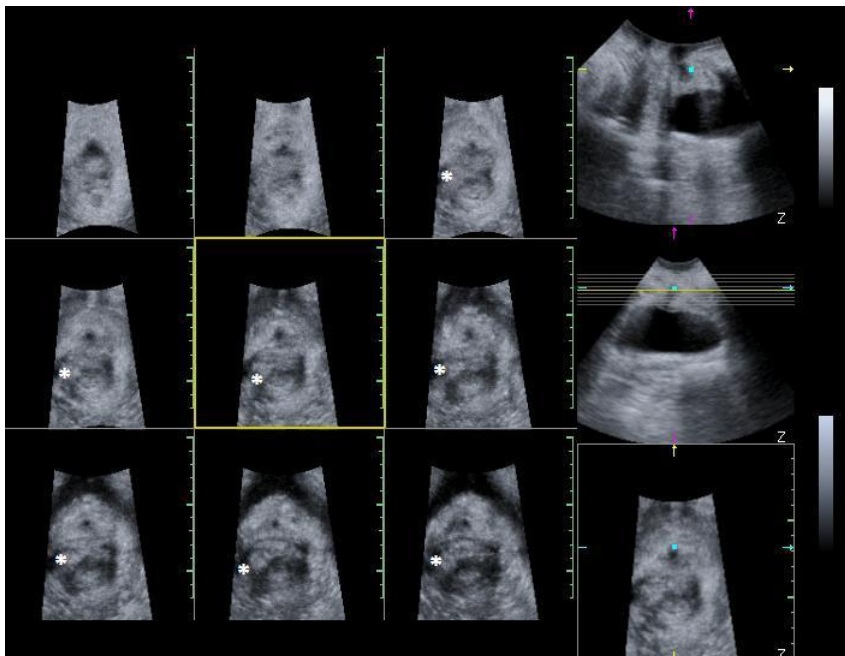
Tomographic ultrasound showing right sided defect, indicated by the asterisk at the insertion site of puborectalis in all 7 slices (slice interval 2.5mm)
